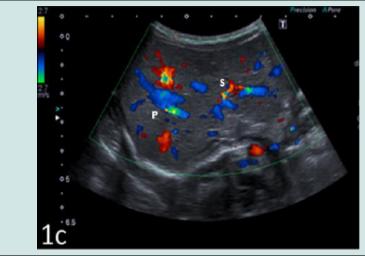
Postnatal ultrasound (45 days): disappearance of the shunt between the right portal vein and the right suprahepatic vein.
